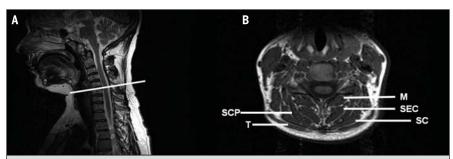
Magnetic resonance images: (A) sagittal cross section of the C6 vertebral level; (B) the corresponding axial scan at the C6 level showing the cervical multifidus (M), semispinalis cervicis (SEC), semispinalis capitis (SCP), splenius capitis (SC), and trapezius (T) muscles.
